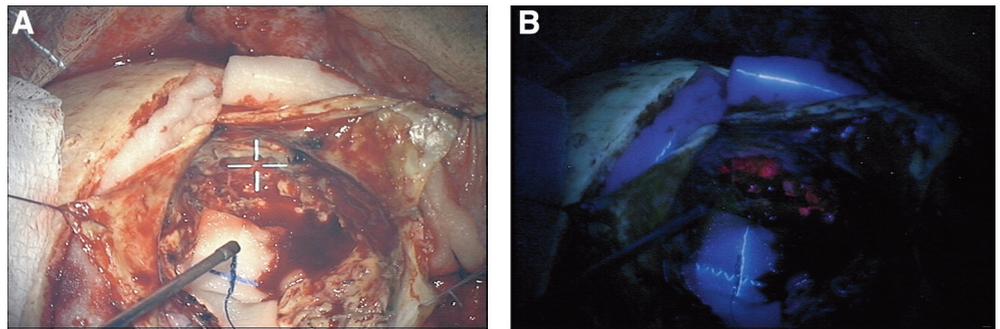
A, near the end of resection of this glioblastoma multiforme, residual tumor is not evident by either image guidance or white light appearance of the tissue. B, under blue light conditions, remaining tumor, corresponding to a portion of the gadolinium-enhancing tumor on MRI, is readily appreciated.
